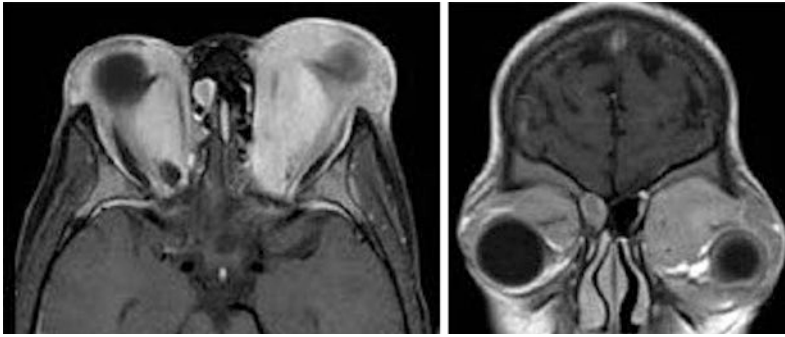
Metastatic neuroblastoma on MR imaging. a Axial and coronal post contrast T1WI with fat suppression demonstrate bilateral orbital extra and intraconal enhancing soft tissue masses with proptosis of both eye globes
